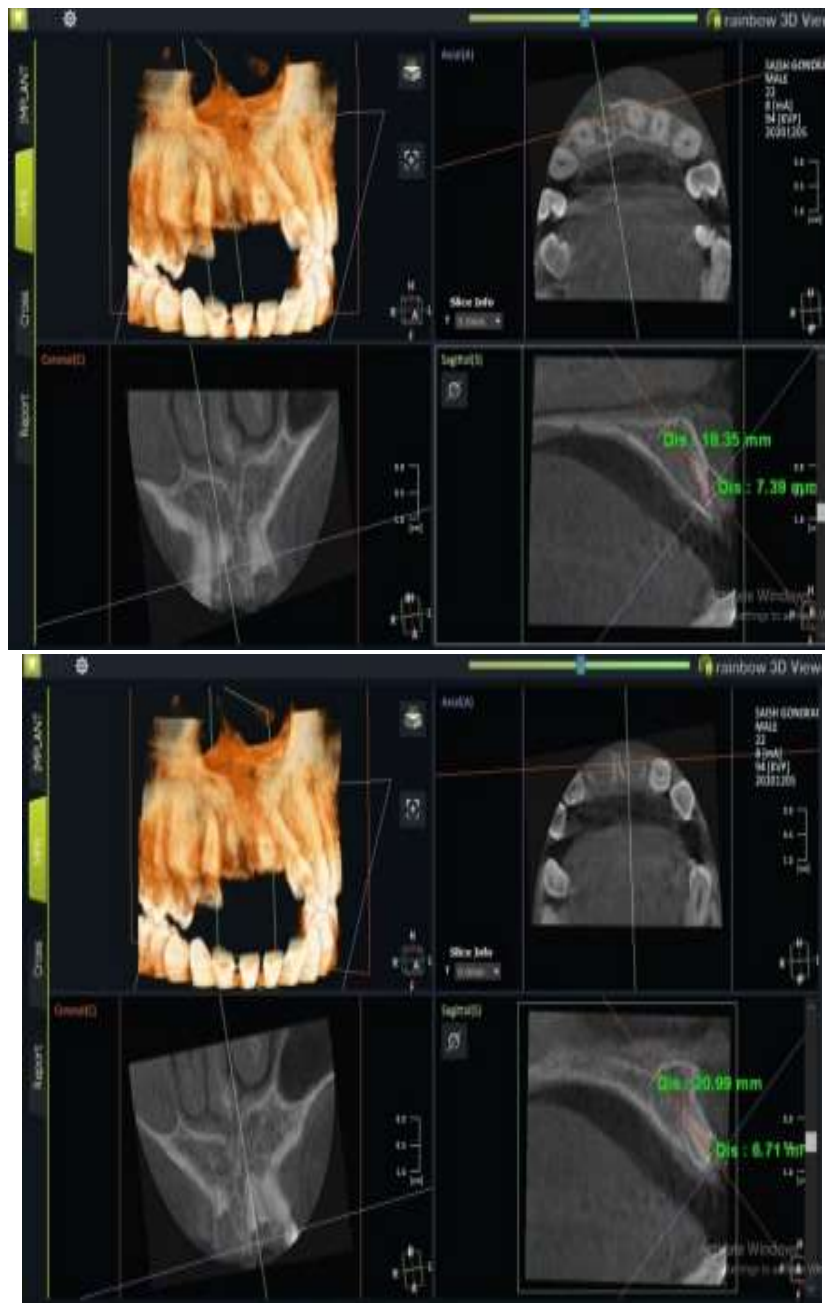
CBCT evaluation for region 11 and 2
